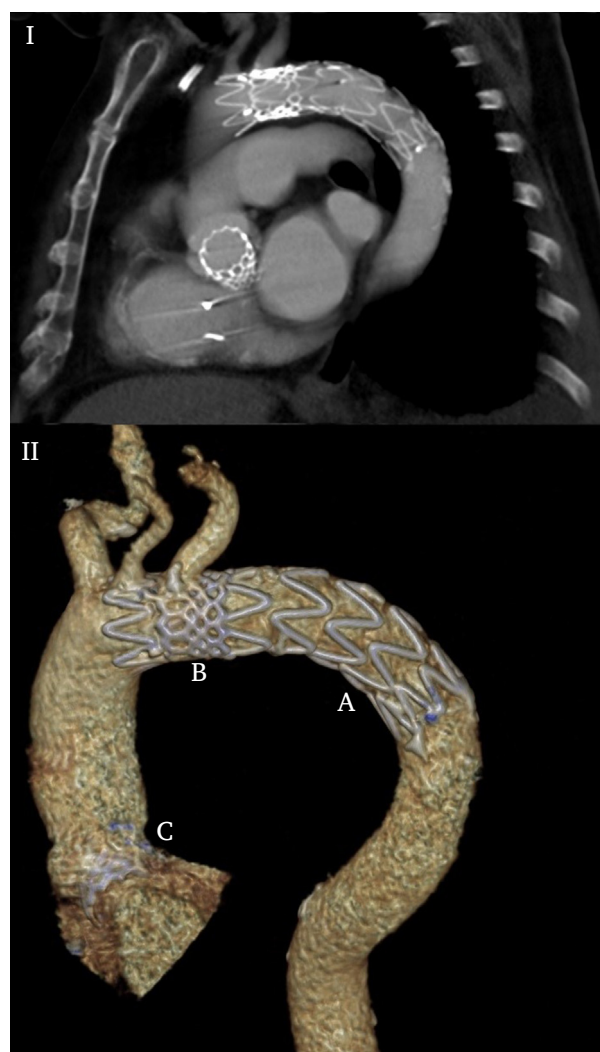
Post-operative computed tomography scan (I) and volume rendered reconstruction (II). Successful in valve thoracic endovascular aortic repair (Valiant™ Captiva™) (A), fixing the dislodged and inverted bioprosthesis distal of the left subclavian artery (LSA) origin (B). Although part of the LSA was overstented, intra-operative fluoroscopy showed sufficient flow to it. A second, functional 26 mm Edwards SAPIEN 3 Ultra aortic bioprosthesis is positioned in the aortic annulus (C).
